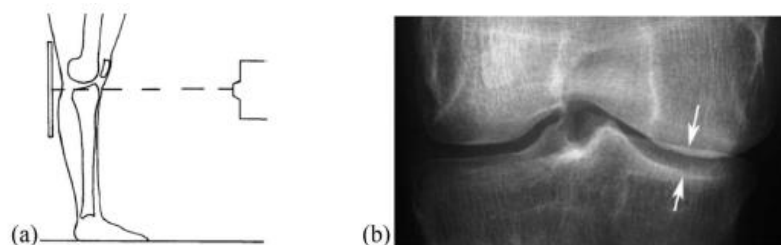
CT arthrography, Knee radiograph with horizontal beam [14]
